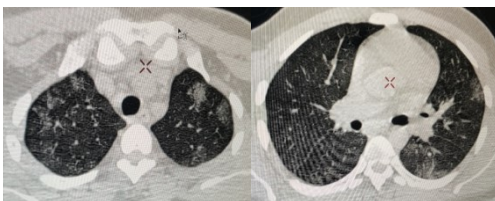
HRCT Chest after 2 weeks of admission
